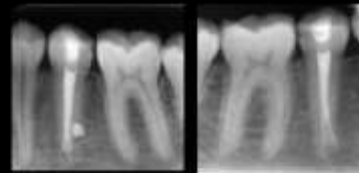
6-months postoperative radiographs of the right and left premolars.
